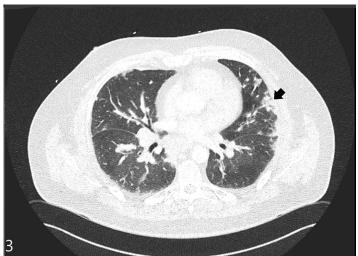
Computed tomography angiography displaying evidence of pleural consolidations (black arrowhead).
